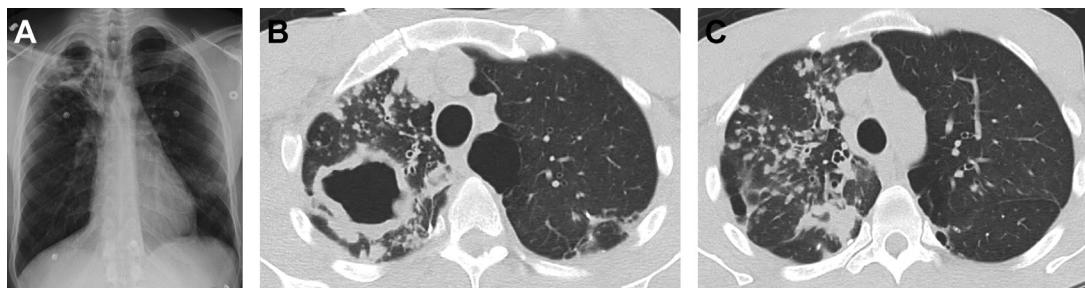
72-year-old man with *M kansasii*. (A) Chest radiograph shows cavitary consolidation in right upper lung with adjacent nodular opacities. (B) and (C), Axial chest CT shows cavity in right apical segment with adjacent centrilobular and tree in bud nodules. Note the underlying paraseptal emphysema.
